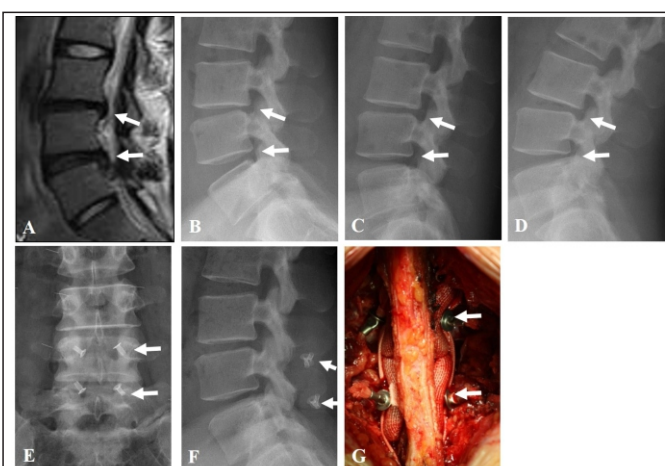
Magnetic resonance image (a) shows moderate lumbar disc herniation at L4-S1 segments. Neutral (b), flexion (c), and extension (d) lateral radiographs show that segmental imbalance, such as hyperlordosis and retrolisthesis, of L4-S1 segments is reduced in flexion but aggravated in extension. Post-operative radiographs (e and f) and clinical photo (g) show limited laminectomy and discectomy and DIAM implantation at L4-S1 segments with restoration of segmental lordosis.
